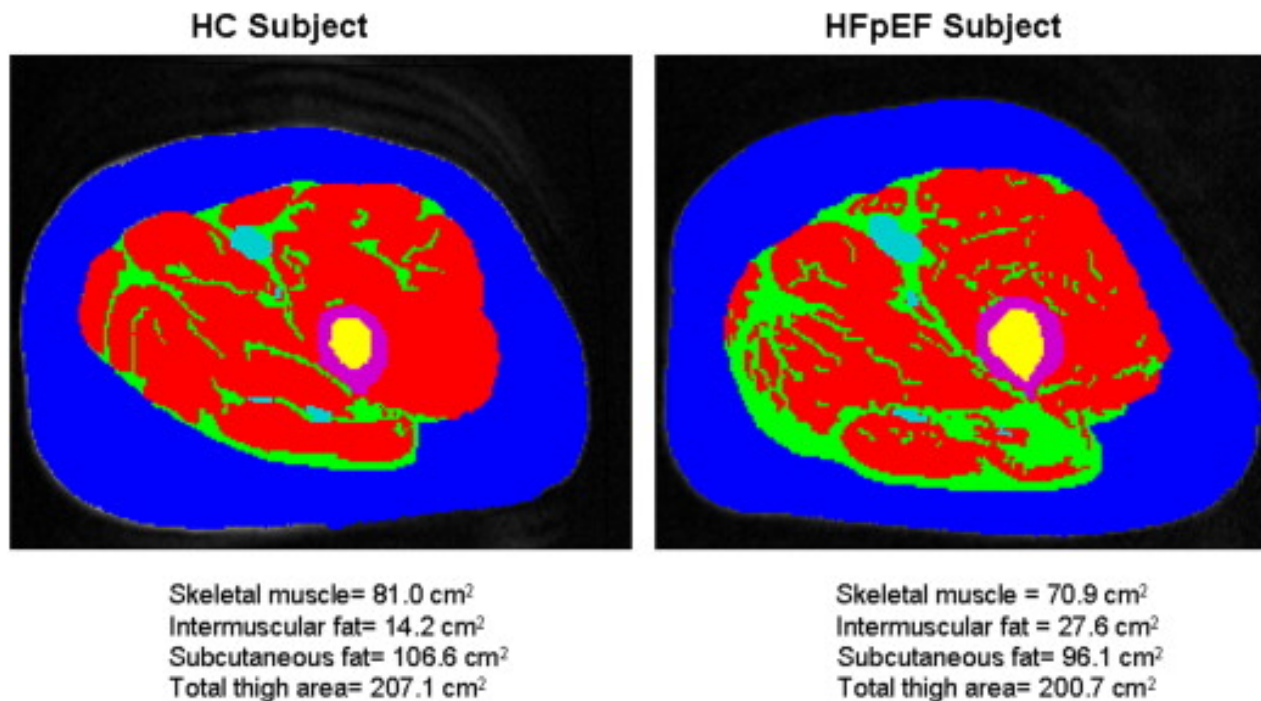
Magnetic resonance imaging axial image of the midthigh in a patient with HFpEF and an HC. Red = SM; green = IMF; blue = SCF; purple = femoral cortex; yellow = femoral medulla. IMF (green) is substantially increased in the patient with ...
